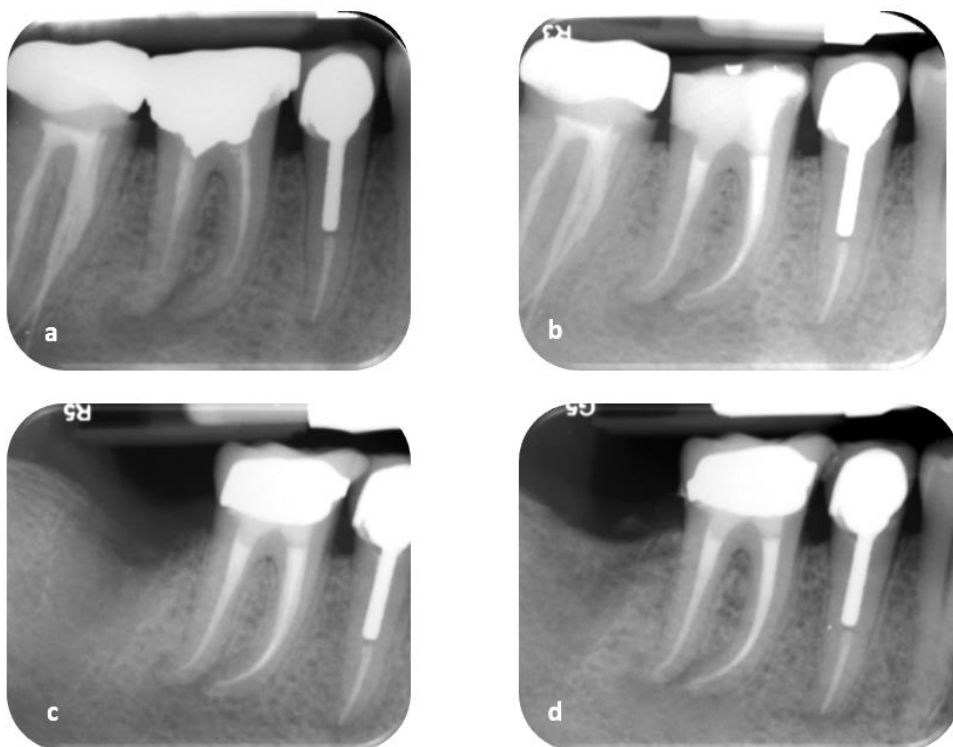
Review of tooth 46 (a) Pre-operative radiograph (b) Postoperative radiograph (c) 1-year review, showing periapical radiolucency is less dense (d) 2-year review, showing further reduction in the density and size of the periapical radiolucency
